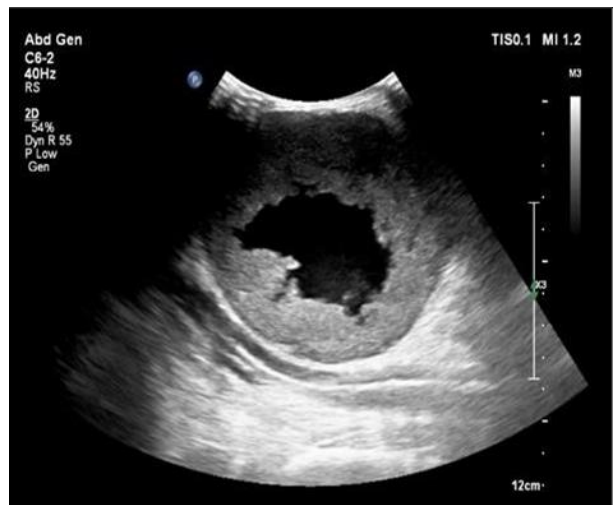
Ultrasound image of swelling
